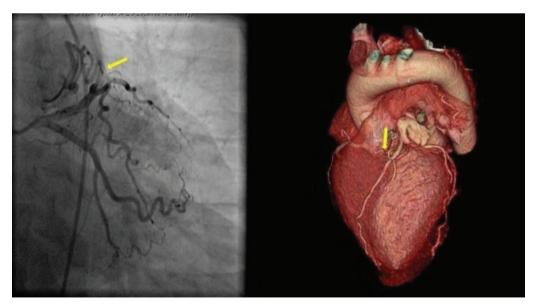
CAG and multislice CT images showing the CAF between the second diagonal branch of the LAD artery and the main PA CAG: Coronary angiography, CT: Computed tomography, CAF: Coronary artery fistula, LAD: Left anterior descending, PA: Pulmonary artery
